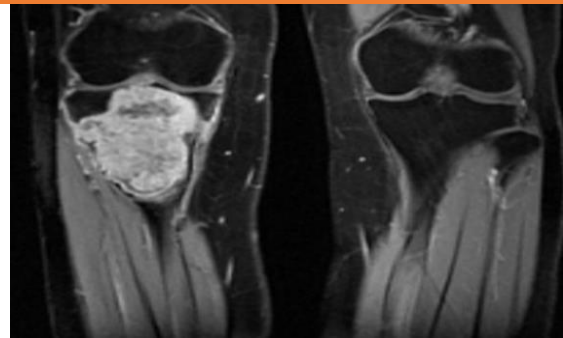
T2 Weighted MRI of lower femur shows a high signal intensity lesion in the metaphysis with cortex is spared.
